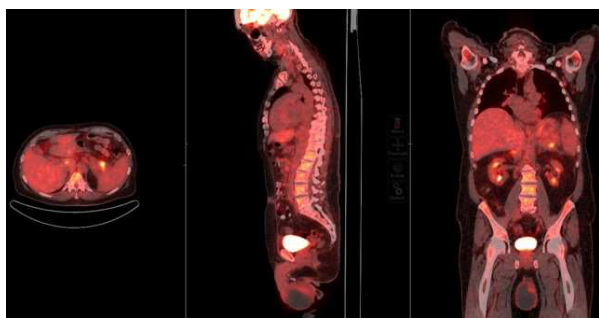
Post-treatment PET/CT scan documenting a response at essentially all the sites previously involved with lymphoma, but demonstrating a focal persistent uptake in the pancreatic tail.
